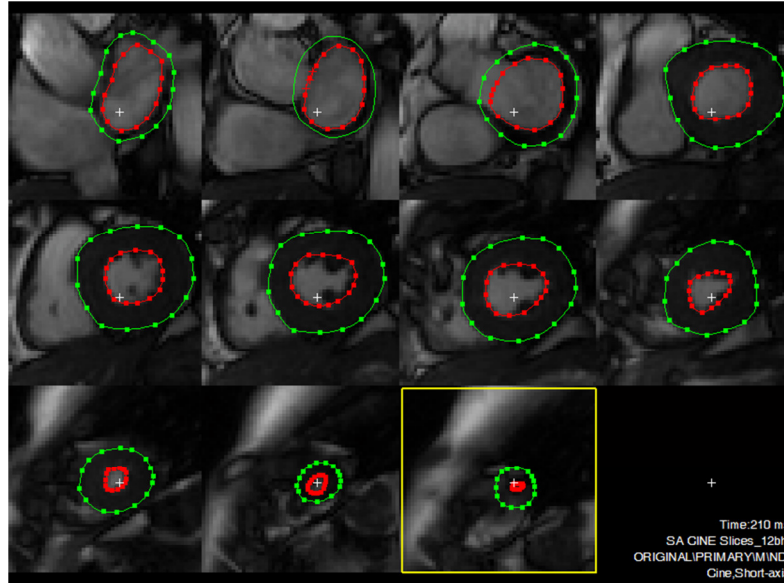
Example Patient MRI images from end-systolic time point with epicardial (green) and endocardial (red) contours of the LV segmented using *Segment*
